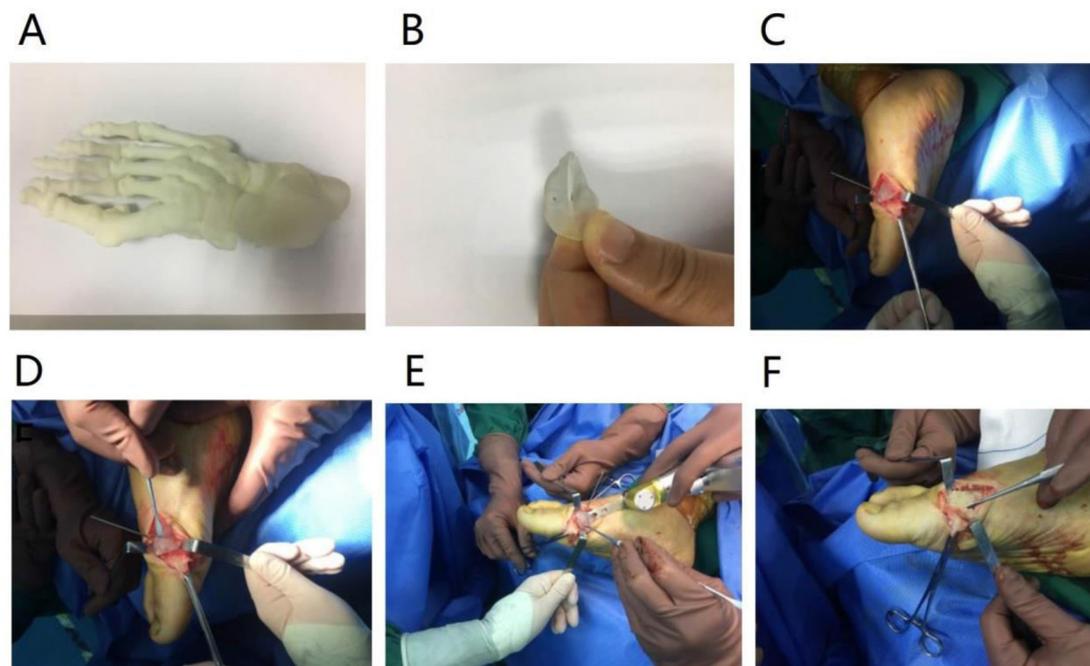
Intraoperative operations of case 2. A: Based on foot CT data before surgery, Geomagic 11.0 was used for editing and printing a 3D model of the foot. B: Before surgery, a navigation template was designed based on the 3D model of the foot and the osteotomy angle, and then printed. C: The bony protrusions was fully exposed. D: the navigation template designed and printed before surgery based on the bony marker device was used, then reinforced with Kirschner wire for stabilization. E: A micro pendulum saw was used to design an osteotomy route based on the navigation template before surgery and then osteotomy was performed. F: Medial view after osteotomy.
